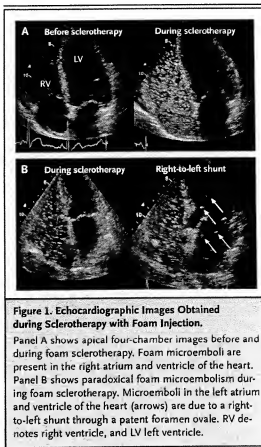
Echocardiographic Images Obtained during Sclerotherapy with Foam Injection.
